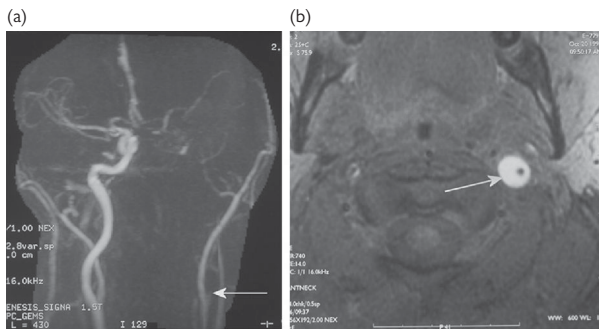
Carotid artery dissection on MRI and MRA. An MRI sequence from a patient with acute left proximal internal carotid artery dissection. (a) MRA demonstrating apparent left internal carotid artery occlusion. This is in fact a pseudo-occlusion caused by compression from thrombus in the false lumen. (b) Axial view through the internal carotid artery in the neck demonstrating a high signal within the arterial wall (recent thrombus) surrounding a small residual lumen (low signal).
